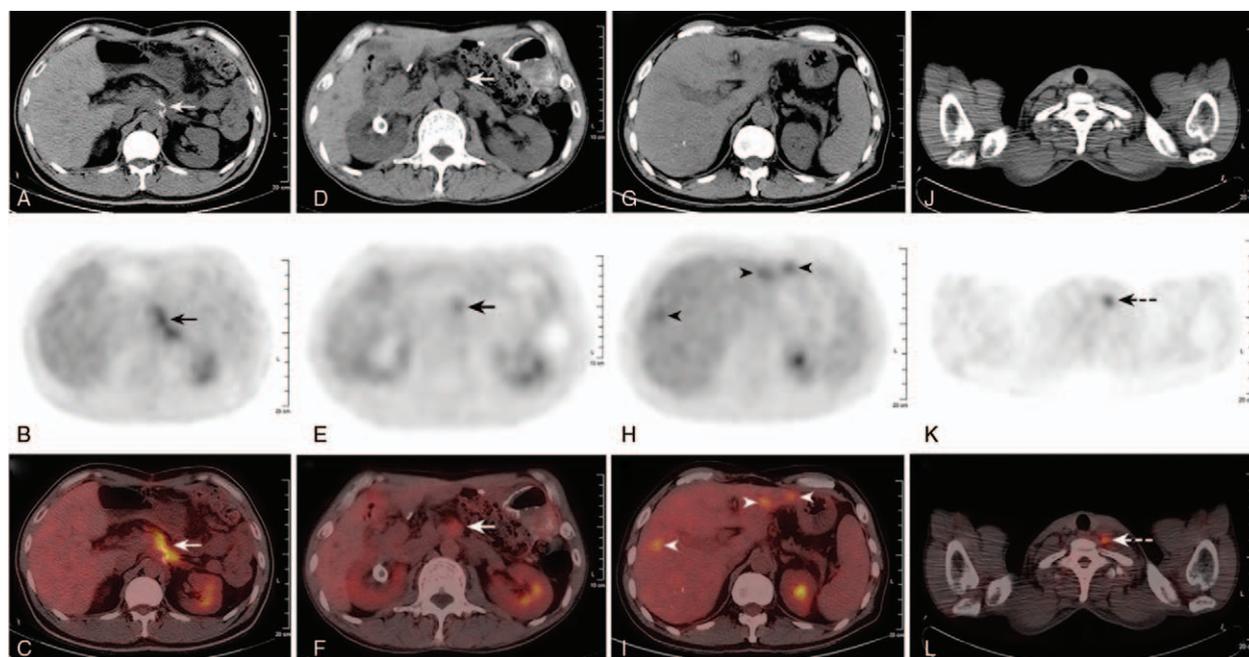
Postoperative FDG PET/CT findings at surgical margin of remnant pancreas (A–C), locoregional lymph node (D–F), and distant sites (G–L). (A) CT image showed the resection margin of remnant pancreas after distal pancreatectomy (thin arrow). (B and C) FDG PET/CT revealed increased FDG uptake at the same site (thin arrows). (D) CT image showed an enlarged para-aortic lymph node with the diameter of 15 mm (thick arrow), (E and F) FDG PET/CT revealed increased FDG uptake at this lymph node (SUV_{max} of 3.2, thick arrows). (G) CT image showed ambiguous low density of liver. (H and I) FDG PET/CT revealed obvious increased FDG uptake of lesions within liver (SUV_{max} of 5.9, arrow heads). (K and L) obvious increased uptake of FDG at left supraclavicular lymph node (SUV_{max} of 4.4, dashed arrows).
